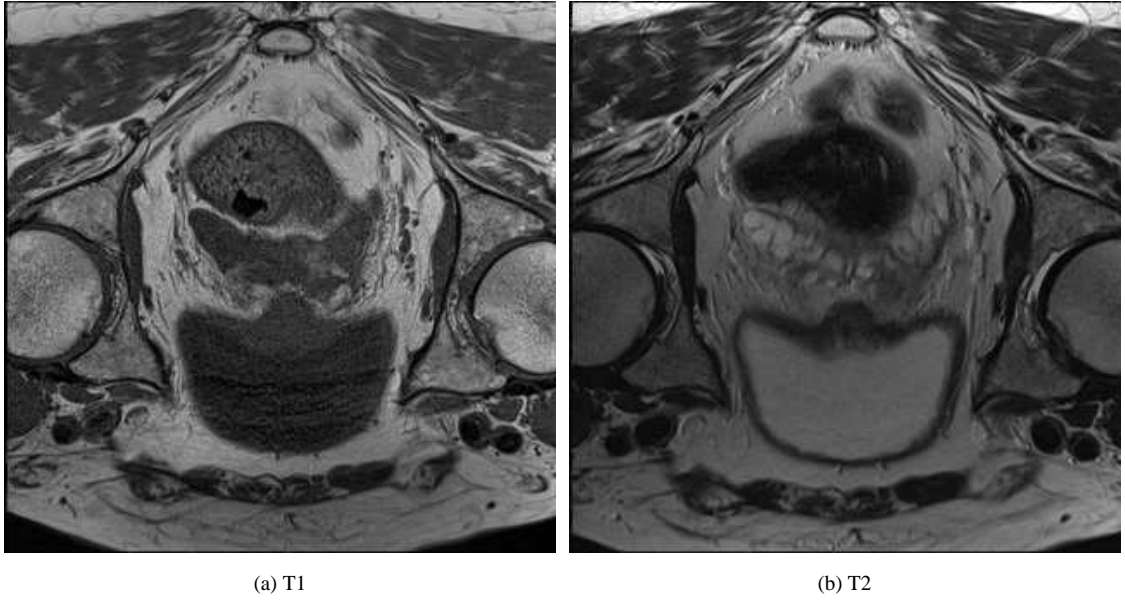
The same anatomy shown with a T1 (a) and T2 (b) weighted MRI image. The large circles at either side of these images are the heads of the femurs. The bladder and rectum are also prominent. The cortical bone shows as a dark line around the boundary of the trabecular bone. This line is more precisely delineated in the T1 image, though the difference is marginal.
